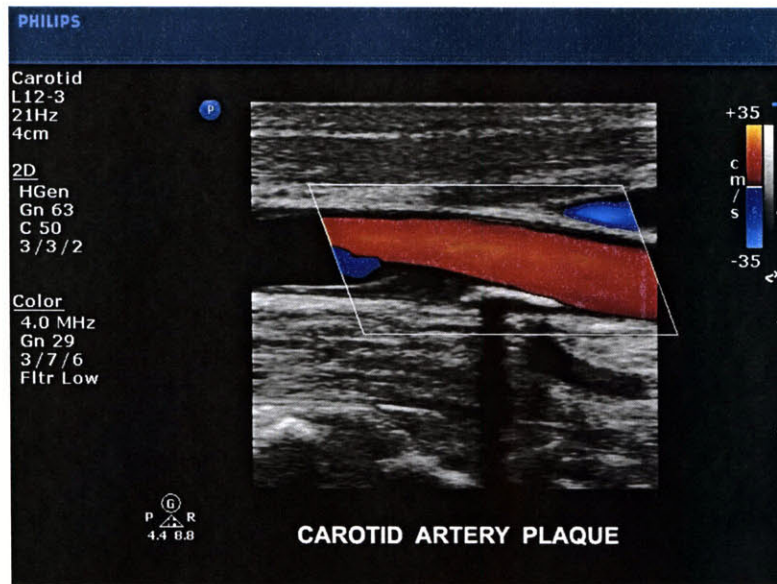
B-mode image with Color Doppler (50)
